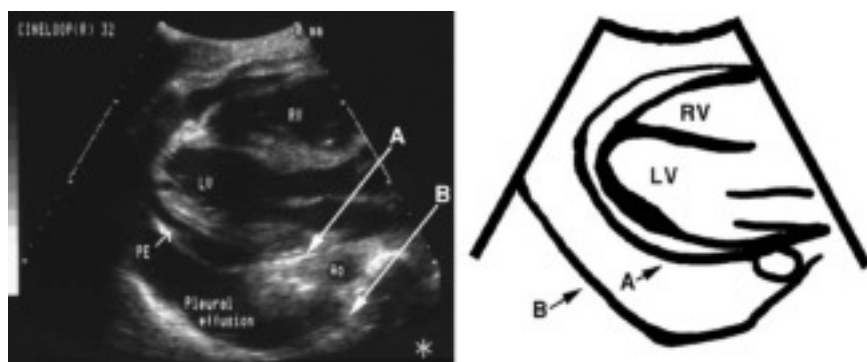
Parasternal long-axis view of a pleuropericardial effusion. Fluid is noted within the pericardium (small arrow and PE), and the descending aorta (Ao) and pleural fluid is noted below this. Arrow A points to the more anterior reflection of the pericardium adjacent to the descending aorta. Arrow B points to the posterior reflection of the pleura adjacent to the descending aorta. LV, left ventricle; PE, pericardial effusion; RV, right ventricle.
